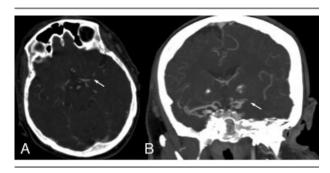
Axial source image (A) and coronal maximal intensity projection (MIP) view (B) of computed tomographic angiography in acute left middle cerebral artery (MCA) occlusion (arrows). Opacification in more distal segments of the proximal MCA on axial source images (A) because of collaterals may be mistaken for patency of the MCA unless MIP views (B) are viewed.
